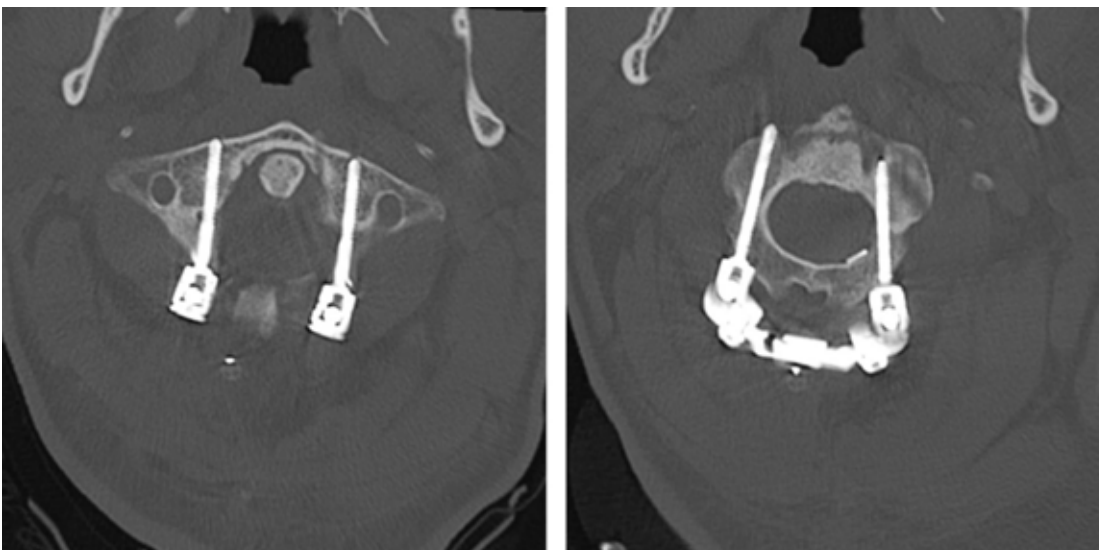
Post-operative axial CT images showing safe placement of C1 lateral mass screws (LEFT) and C2 pedicle screws (RIGHT).
